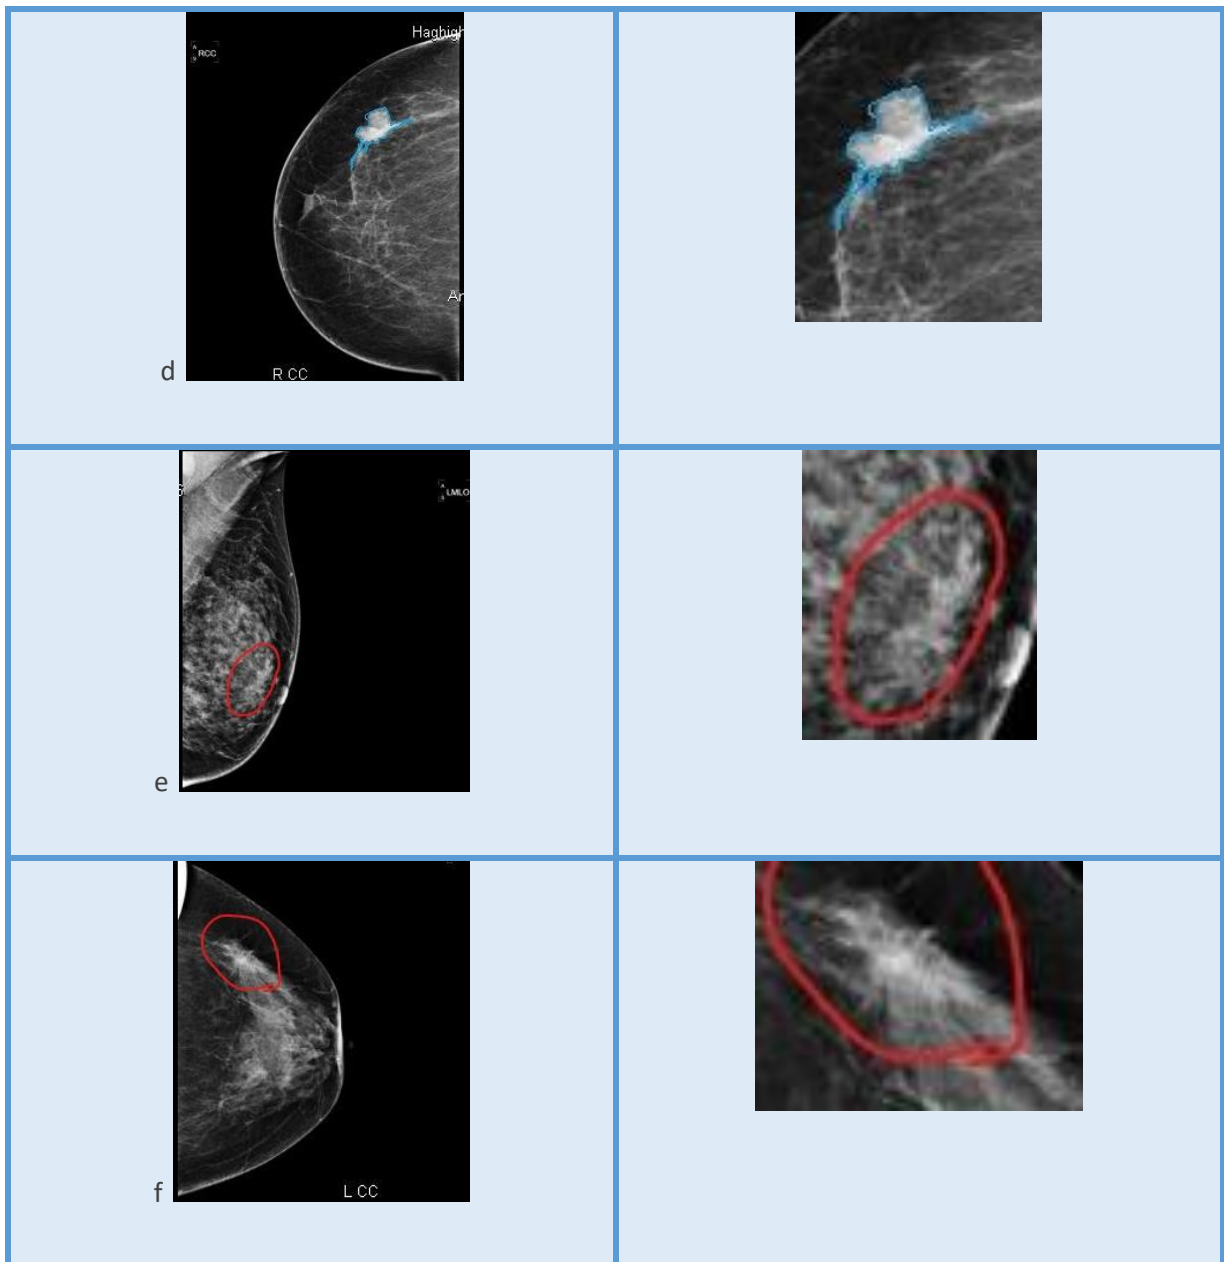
Mass with different BIRAD: B0) Mentioning incomplete study as it may be overlapping layer of breast tissue and it should be checked in another modality, B2) Benign mass as patient has medical history and the mass is stable comparing previous Mammography, B3) There is no previous Mammography(no medical history) to compare this mass with that one, B4a)Speculated mass, B4b)Mass with more speculation comparing to B4a, B4c)Mass with sever speculations, B5)Speculated mass that has been checked in ultrasound and in ultrasound specialist still found more speculations also there are some micro calcifications on the mass .
